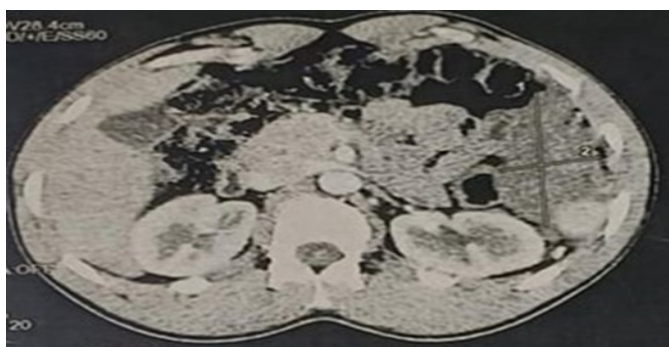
CT scan of the abdomen showing the mass of the left hypochondrium
